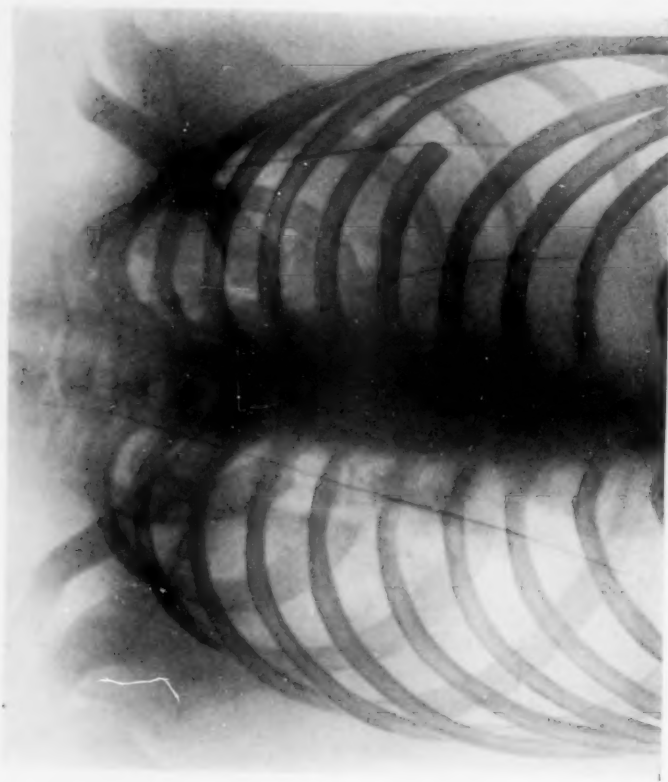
The end-result in the case shown in Fig. 7. (X-ray taken one month after operation.) The defect in the rib shows the extent of the rib resection in this case. The cavity is obliterated. The shadow cast by the thickened pleura has entirely disappeared.
